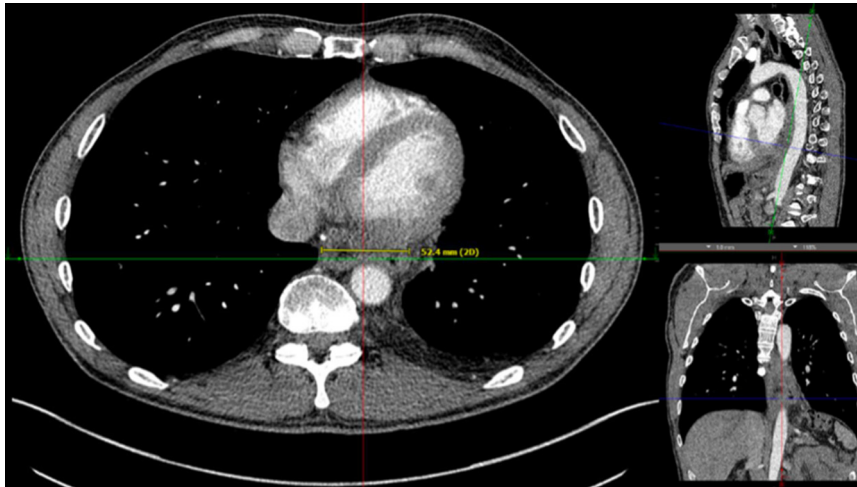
Radiographical measurement of maximum intrathoracic conduit width (centimeters)
